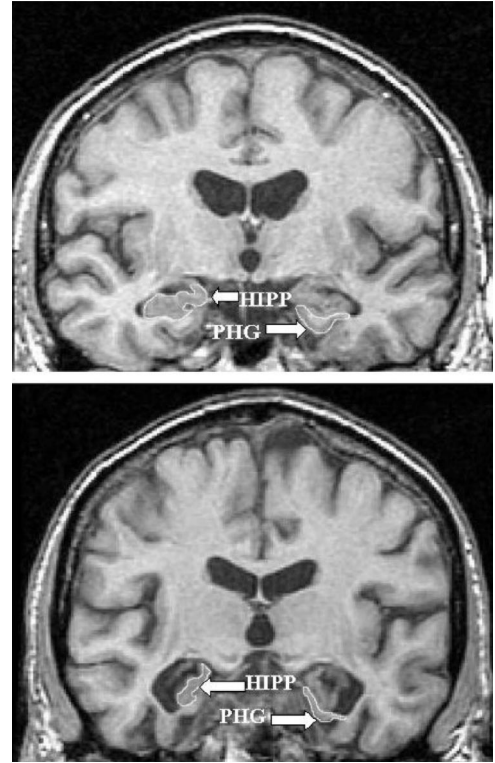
Baseline coronal MRI slices, 2 mm posterior to the hippocampal-amygdalar junction, showing the tracings for anterior hippocampus and parahippocampal gyrus. Upper image: 70-year-old healthy control male subject. Lower image: 67-year-old male patient with mild cognitive impairment who subsequently converted to Alzheimer disease. HIPP = hippocampus; PHG = parahippocampal gyrus.
